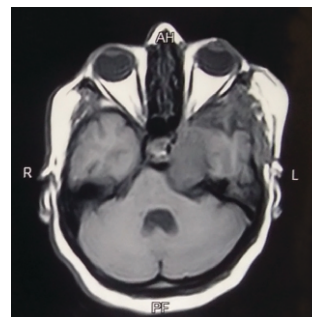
T1 weighted MRI image showing tumor invasion into para-pharyngeal space and infratemporal fossa
